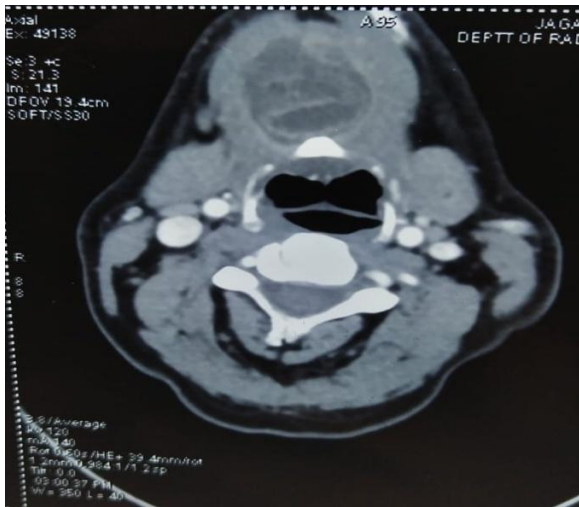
Axial computed tomography (CT) scan shows an oval well-defined lesion with thick septae with crano-caudal extent of 4.5cm in submental region and right sublingual region. The lesion showed curvilinear hyperdense membrane and multiple round more hypodense areas in between.
